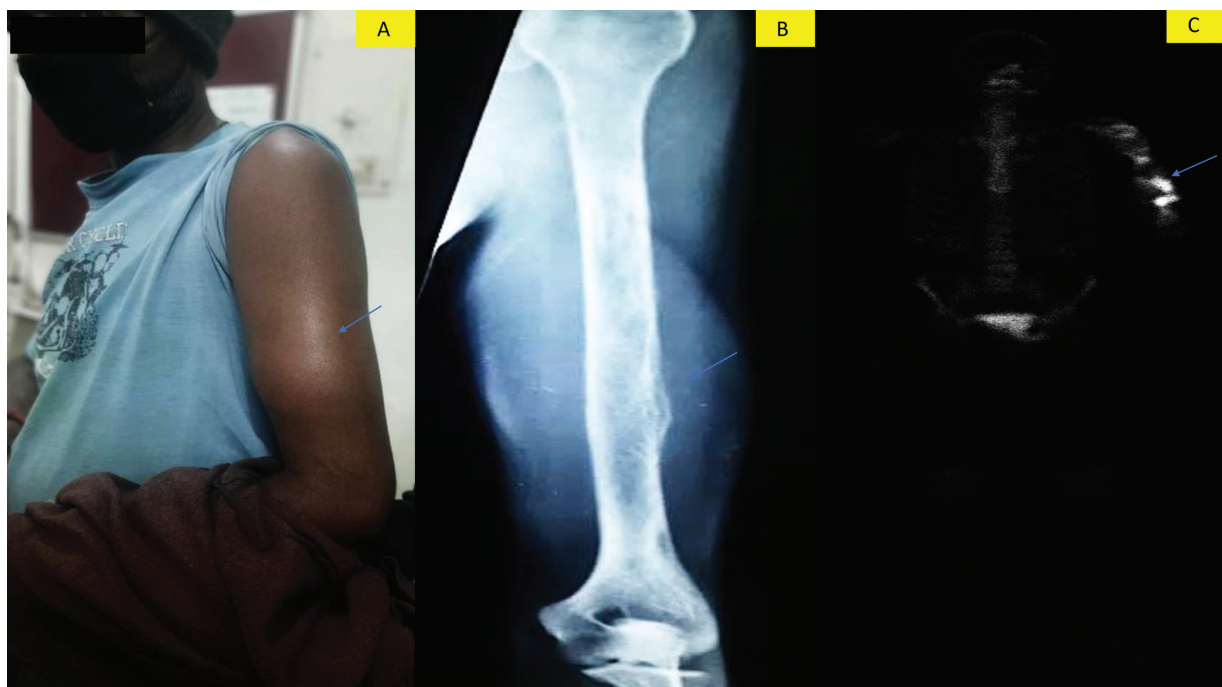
(A) Clinical photograph of the patient. (B) X-ray of the left arm. (C) Fluorodeoxyglucose positron emission tomography-computed tomography whole body imaging.
